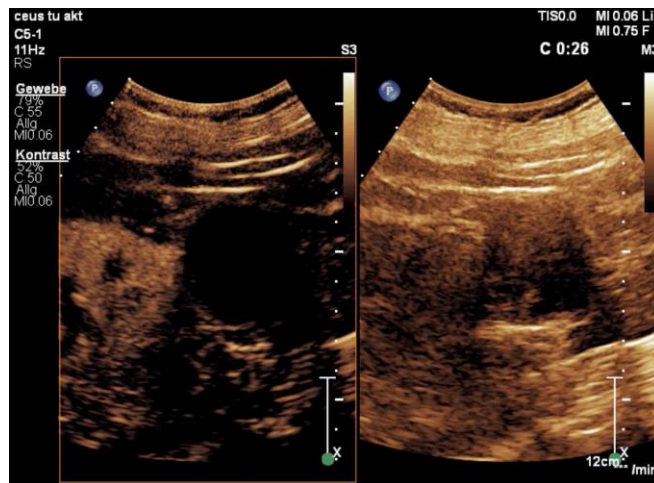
In CECT and CEMR suspicion of malignant tumour. Inhomogenous echoic formation in B-mode (a). Contrast-enhanced ultrasound: no perfusion, simple cysts with bleeding, Bosniak 2 (b). Contrast-enhanced ultrasound: TIC (Time intensity curve): no perfusion in bleeding cyst (blue) and cortex perfusion (red). (c).
